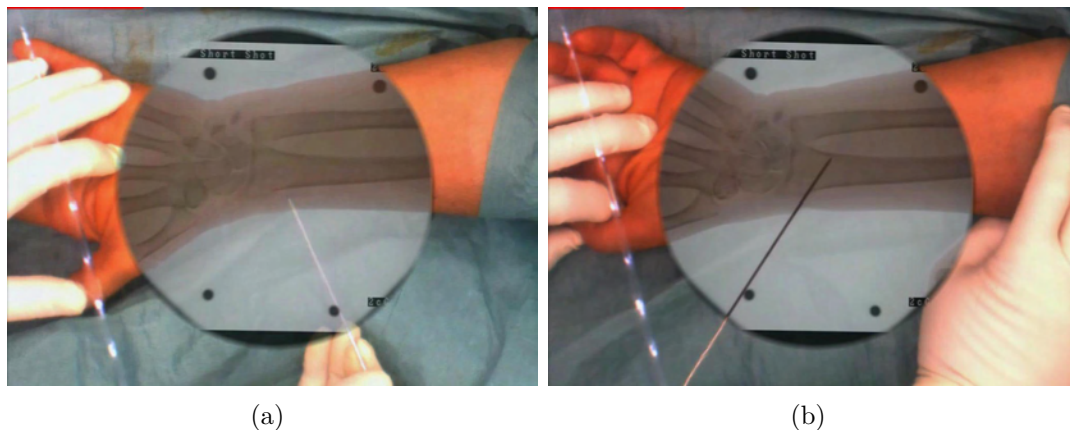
(a) Placing a K-wire relative to fractures of the distal radius using the X-ray and video image overlay; (b) Confirmation of the K-wire placement.
